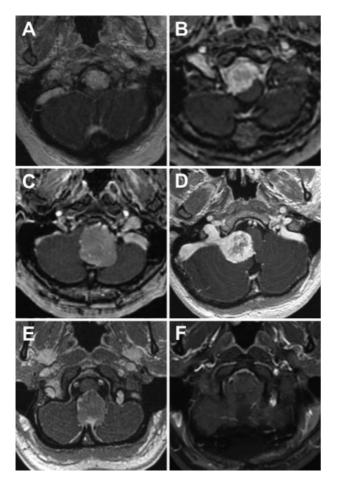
Case examples with post-contrast T1-weighted magnetic resonance imaging of foramen magnum meningioma locations. (A) Anterior, (B) anterolateral, (C) lateral, (D) posterolateral, (E) posterior, and (F) postoperative scan from the posterior foramen magnum meningiomas.
